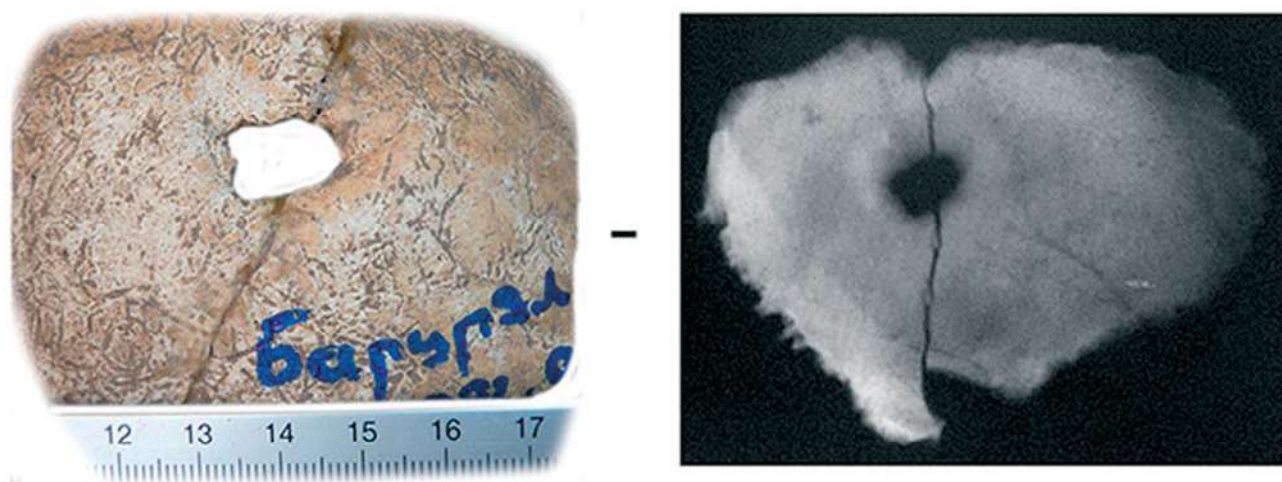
Trepanation with sawing: a skull of a 20–29-year-old individual from Bardzryal, Burial no.9 (left picture). X-ray of the same skull (right picture; Khudaverdyan 2016).
